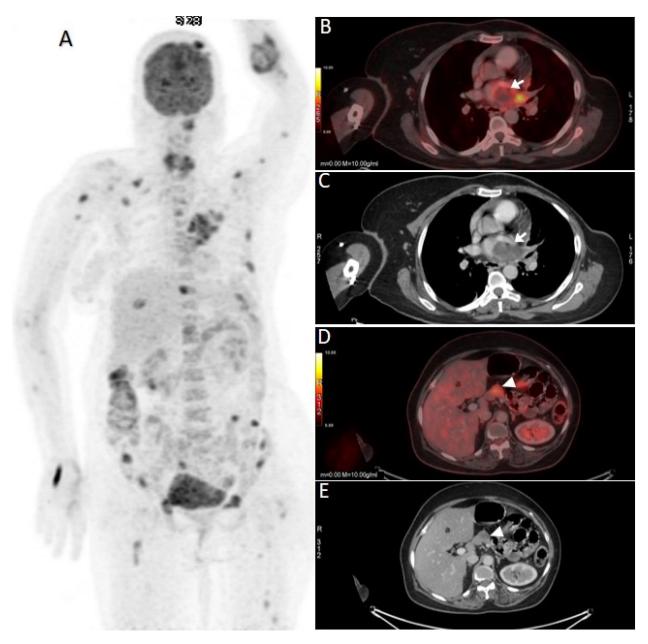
PET-CT images of patient diagnosed with malignant phyllodes tumor. A) Maximum intensity projection image showing multiple foci of abnormal FDG uptake. B) & C) coregistered PET-CT image and CECT images respectively showing tumor thrombus in left atrium (white arrows) and D) & E) coregistered PET-CT image and CECT images respectively showing FDG avid hypodense lesion in pancreatic head (white arrowheads).
